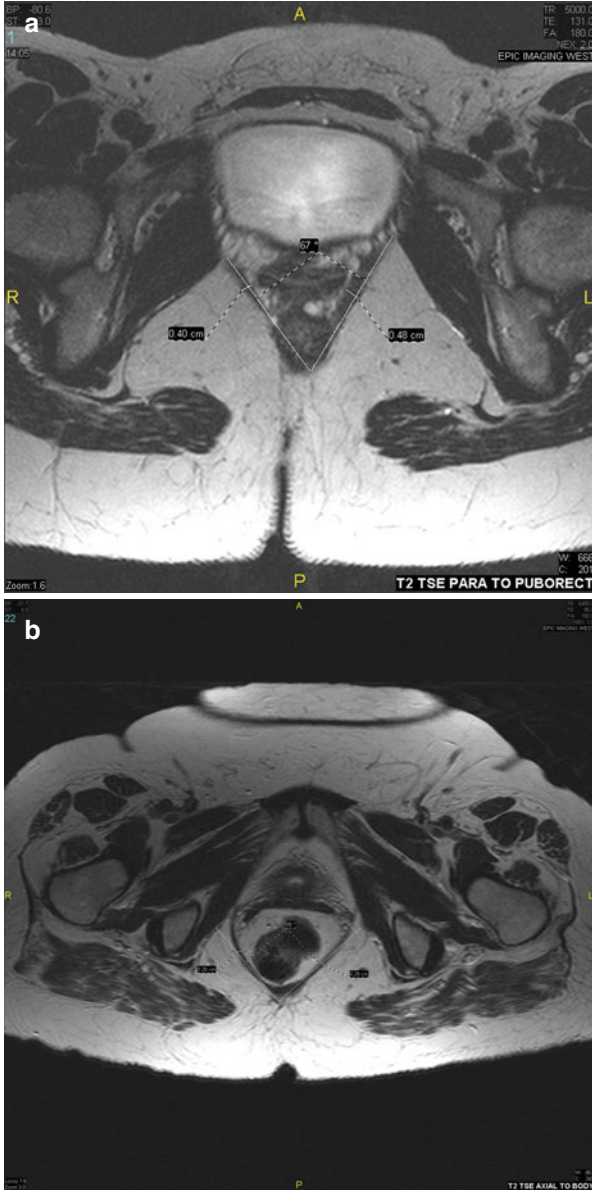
MRI of the levator hiatus, normal on the top (a) and enlarged on the bottom (b). The angle between the two lines drawn along the puborectalis muscle and bisecting in the posterior midline of the levator ani defines the levator hiatus angle. This angle can also be measured by endorectal ultrasound and is found to correlate with findings of enterocele and pelvic floor prolapse findings on MRI and cystodefecography
